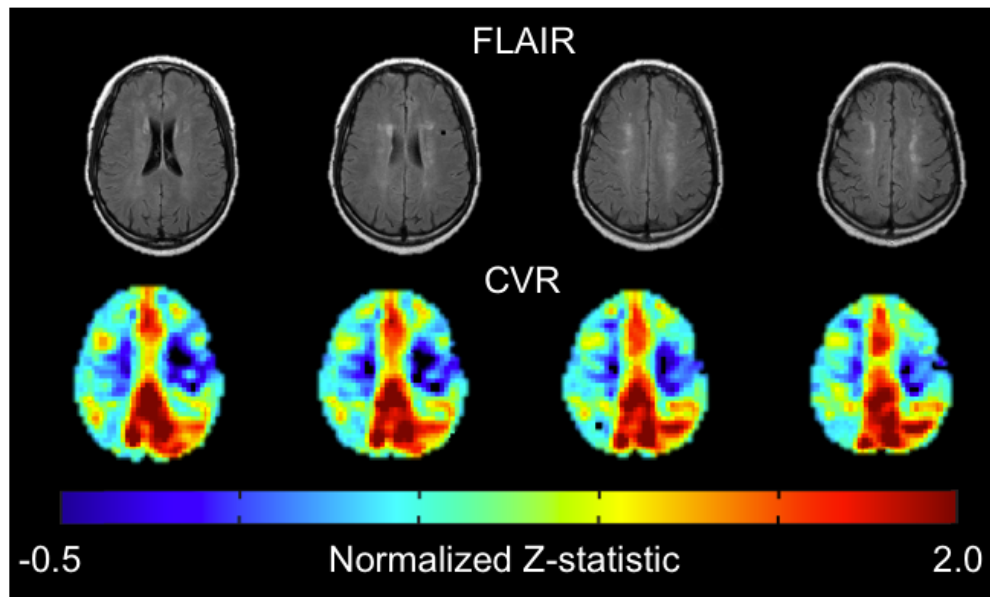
FLAIR and BOLD examples in moyamoya. On the top panel, structural imaging shows bilateral chronic infarcts. BOLD imaging shows bilaterally decreased cerebrovascular reactivity (CVR). Posterior CVR is preserved, consistent with moyamoya disease affecting anterior, but not posterior, circulation. This patient went on to have bilateral revascularizations. The z-statistic values are normalized to whole brain CVR.
